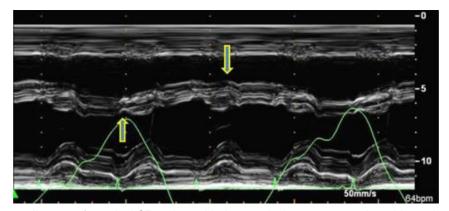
M-mode echocardiogram of a typical CP patient with the ventricular septum moving with respiration toward the left ventricle with inspiration (*upward arrow*) and toward the right ventricle with expiration (*downward arrow*). A simultaneous respirometric recording is shown at the *bottom* of the figure. Video 19 (available at www.onlinejase.com) shows the "septal bounce" on 2D echocardiography in the apical four-chamber view.
